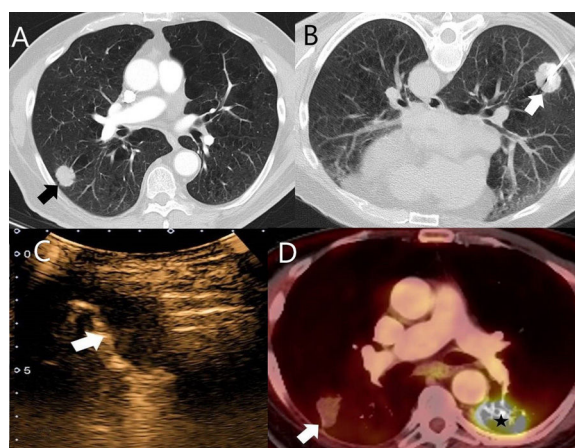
(A) Chest CT with iodinated IV contrast: lung window. A solid subpleural nodule (arrow) is seen in a patient with metastatic disease of cutaneous squamous cell carcinoma of the basal cells. This node was treated using CT-guided RFA. (B) Axial slice with patient in a supine position during CT-guided RFA. An umbrella needle (arrow) was used. (C) Pulmonary CEUS of the same lesion. No contrast uptake is observed throughout the procedure, indicating a complete response to ablative treatment. (D) Chest PET-CT of the same patient 1 year after ablative treatment, showing a decrease in the size of the treated lesion and no FDG uptake (arrow), consistent with a complete response. A pathological increase in FDG was observed in the left lower lobe lesion treated with radiation therapy (star).
